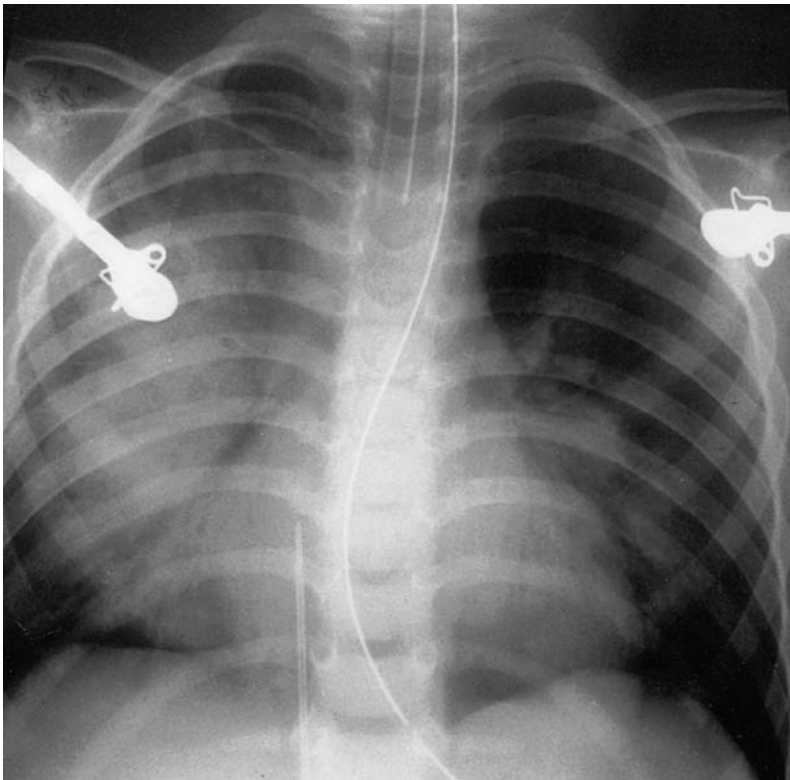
Chest radiograph showing proper endotracheal tube placement at T2 to T3 vertebral level.
